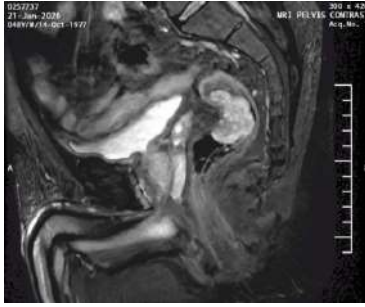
MRI showing large rectal polyp with wide base
